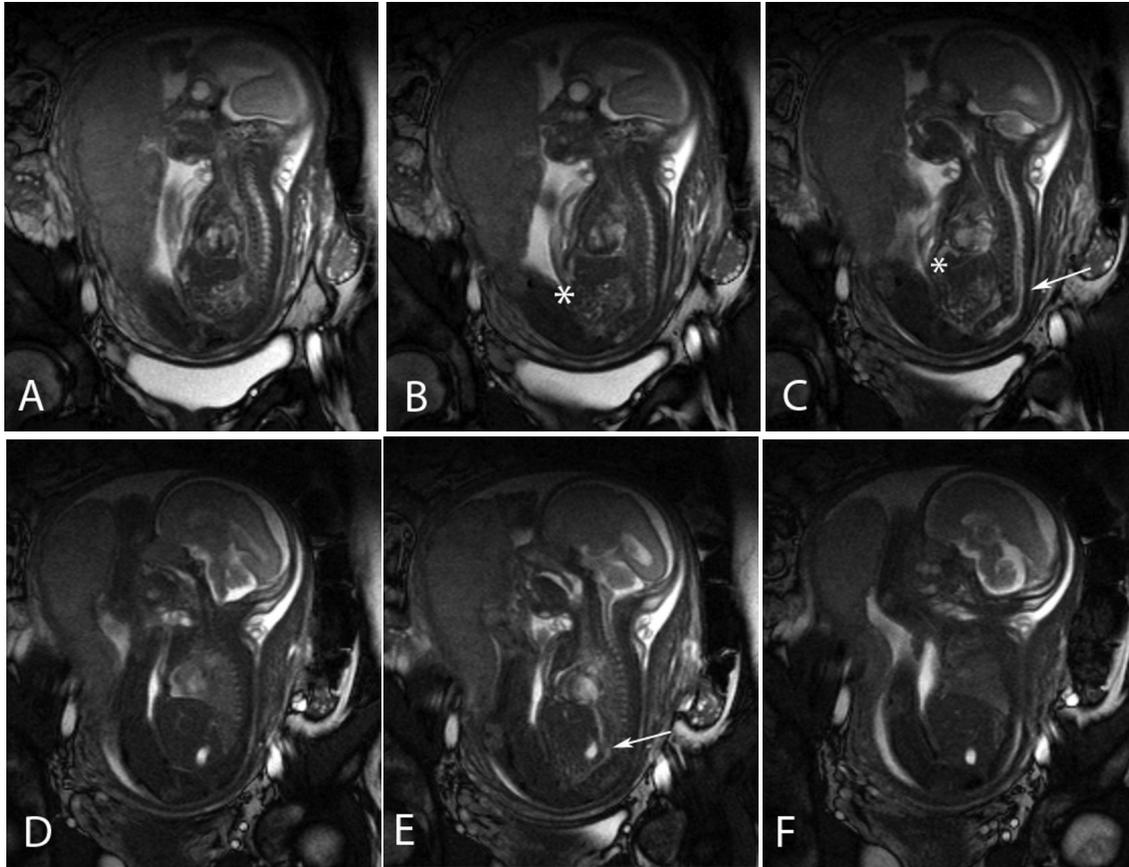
24-week-old fetal female with sirenomelia. Sagittal T2 MR images demonstrate fused lower extremities (D), absent kidneys, absent urinary bladder, lumbar hemivertebra resulting in focal kyphosis (C, arrow), and oligohydramnios. Abnormal high insertion of the umbilical vein is present (B, C; star). Gallbladder is also noted (E, arrow).
